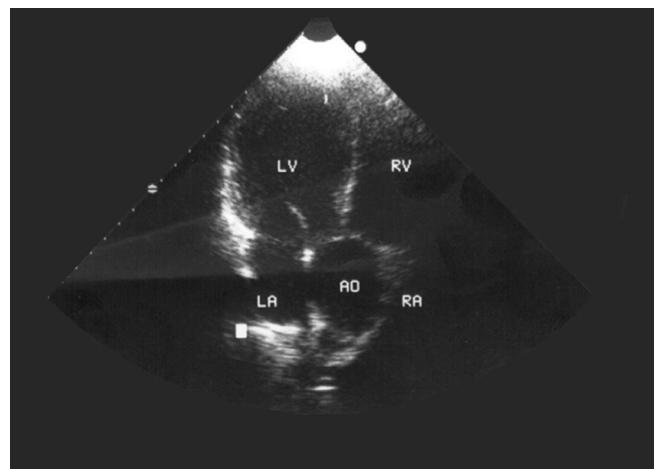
Parasternal view of echocardiography, showing aortic root dilatation AO, Aorta; LA, Left atrium; LV, Left ventricle; RA, Right atrium; RV, Right ventricle
